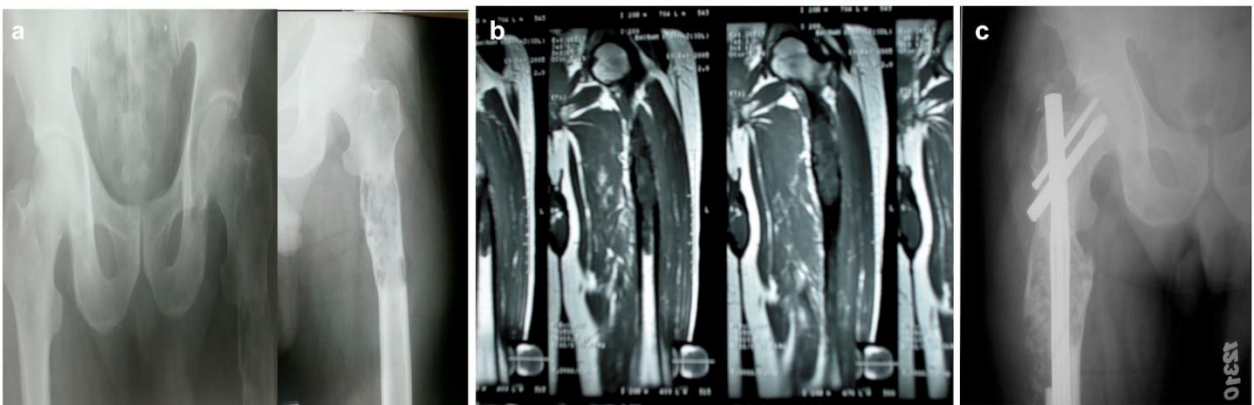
Preoperative X-ray (a) and MR images (b) of a 66-year-old male patient with a spinal hydatid cyst showing lytic lesions on the proximal femur in the hip joint. Postoperative X-ray image (c) showing the excised lesion and femoral nails used for fixation.
